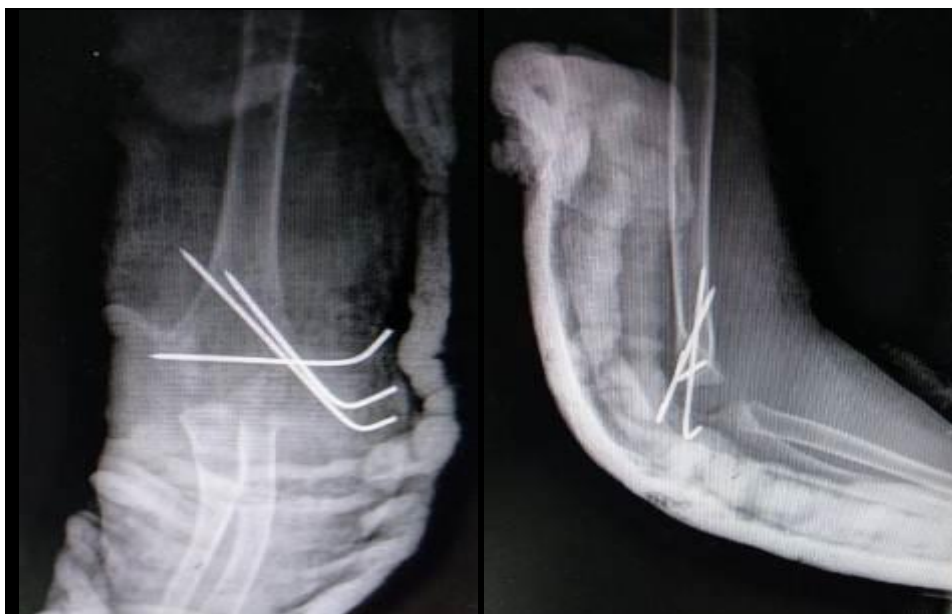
Postoperative x-rays of case no. 2
